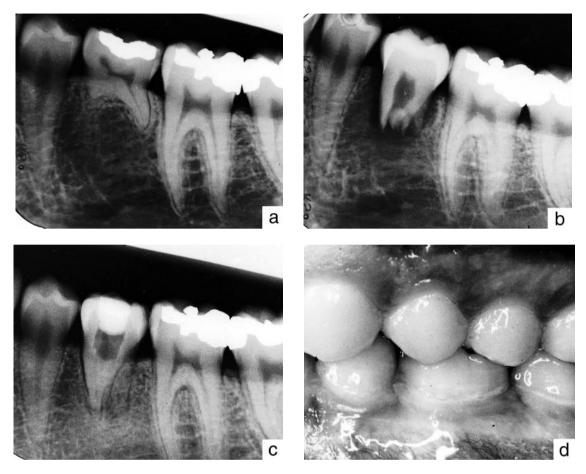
Sequential radiographs of a patient aged 19 years (a,b) and 24 years (c,d). At age 19 the lower right second primary molar was extracted and the upper right third molar was transplanted into the site. A good occlusion was achieved (d).
